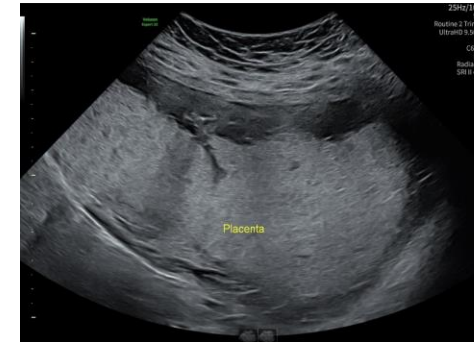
+ 1b: Ultrasound images of marked placentomegaly (1a), and fetal echogenic bowel (1b)
